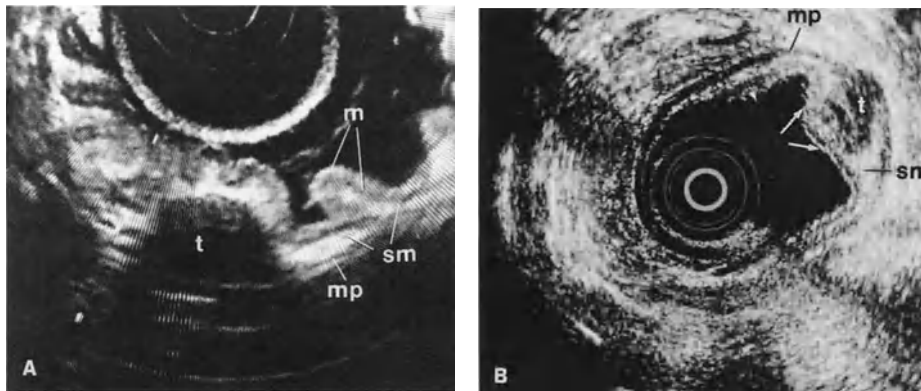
A, B. Endoscopic sonograms. A Local thickening of the muscularis propria (*mp*), seen as a sharply demarcated hypoechoic structure (*t*) originating from the muscularis propria below normal mucosa (*m*). B A clearly demarcated hypoechoic echo pattern (*t*) in the submucosal layer (*sm*), with corresponding bulging of the mucosal layer (*arrows*)
